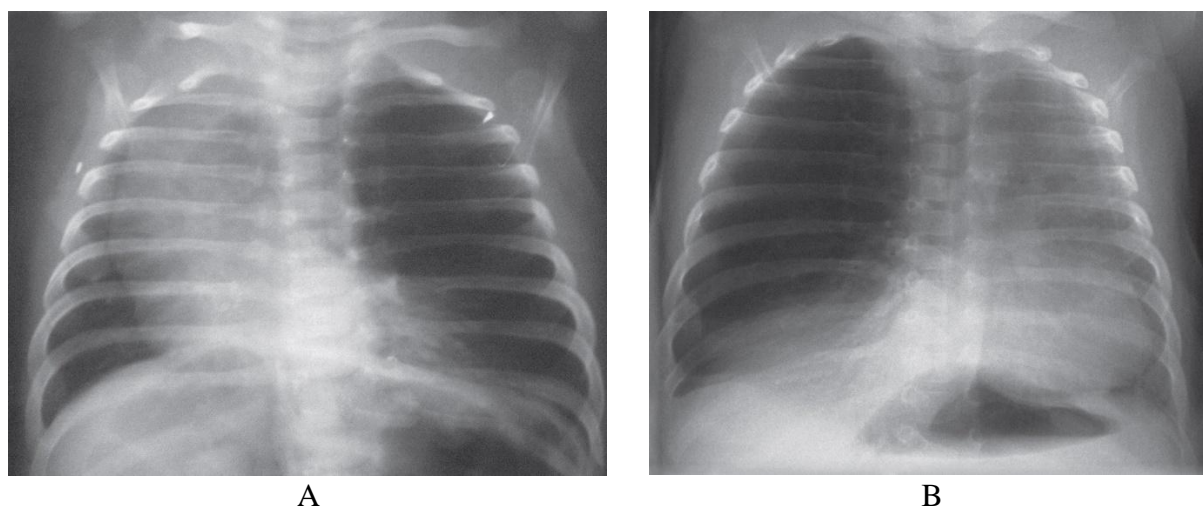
Chest radiographs showing congenital emphysema of superior (S1–S3) segments of left upper lobe (A) and congenital emphysema of right upper lobe (B). There is increased translucency of the lung field on the affected side, and a diminished vascular pattern with shift of mediastinum to the opposite side—pseudodextrocardia (A). There is also ipsilateral flattening of the diaphragm cupola and widening of the intercostal spaces. The contralateral lung field is reduced and has diminished translucency.
